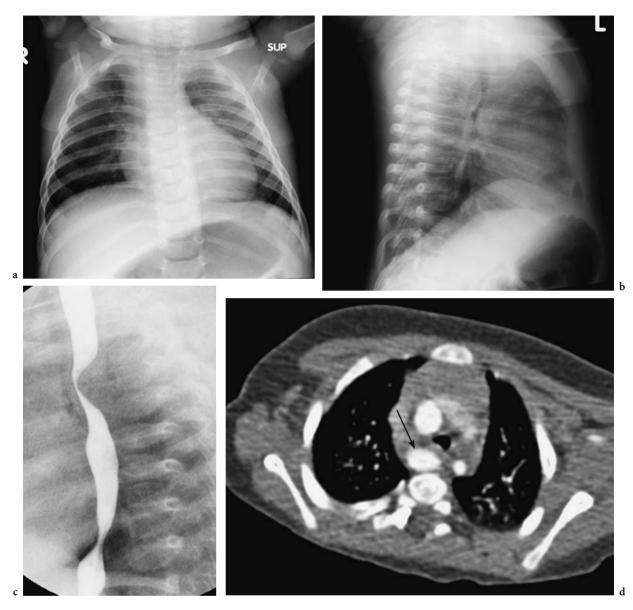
Esophageal duplication cyst. a AP chest radiograph without appreciable abnormality. b Lateral chest radiograph with anterior bowing and narrowing of the airway above the carina. c Barium esophagram confirms the presence of a soft tissue mass. d Contrast-enhanced CT shows the cyst posterior to the airway, and deforming the airway (*arrow*)
